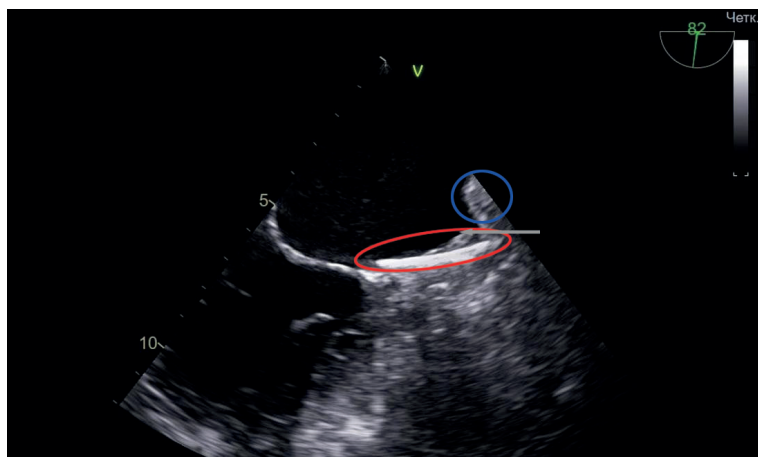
Transesophageal echocardiography after endovascular occlusion of the left atrial appendage. Residual cavity (gray arrow) between the ridge (blue oval) and the occluder (red oval).
